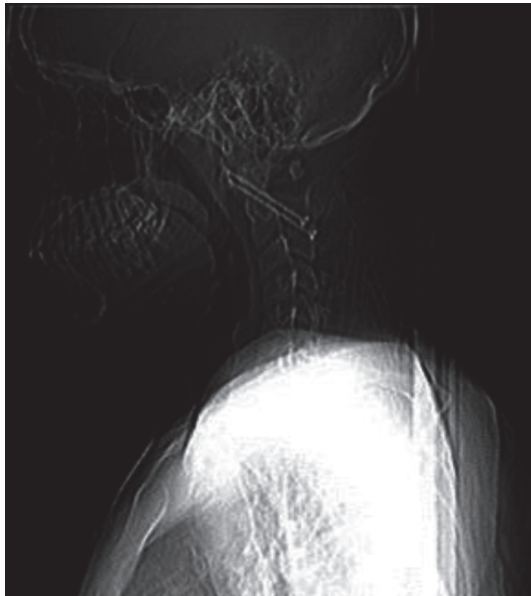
Postoperative Lateral X-ray after Transarticular Screw Insertion
